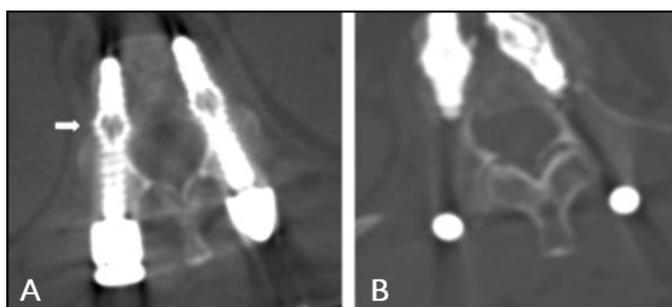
CT images showing expandable pedicle screws (A) and (B). The arrow indicates the expansion zone within the vertebral body [34]
